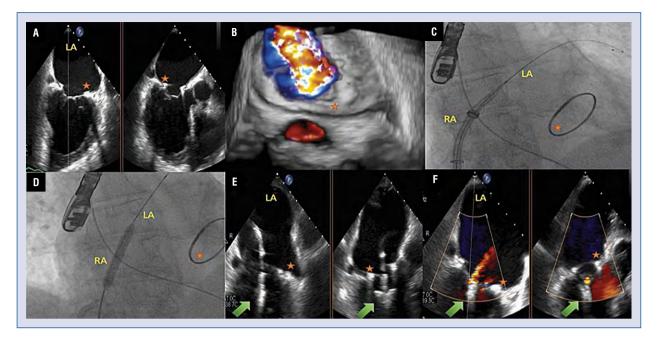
Electrocautery and septostomy facilitated MitraClip in ring; A. Baseline transesophageal echocardiography (TEE) bi-plane view depicting mitral valve (MV) ring position and leaflet tethering; B. Baseline three-dimensional TEE anatomical MV view demonstrating high-grade mitral regurgitation (MR); C. Fluoroscopy showing successful crossing of the fossa ovalis and positioning of a 0.035" wire in the left upper pulmonary vein; D. Balloon atrial septostomy facilitating advancement of the MitraClip delivery system; E. Positioning of the NTW Clip between P2/A2 scallops; F. Final result showing only trivial MR; LA — left atrium; RA — right atrium; Green arrow indicates the Clip; Orange star depicts MV ring position.
